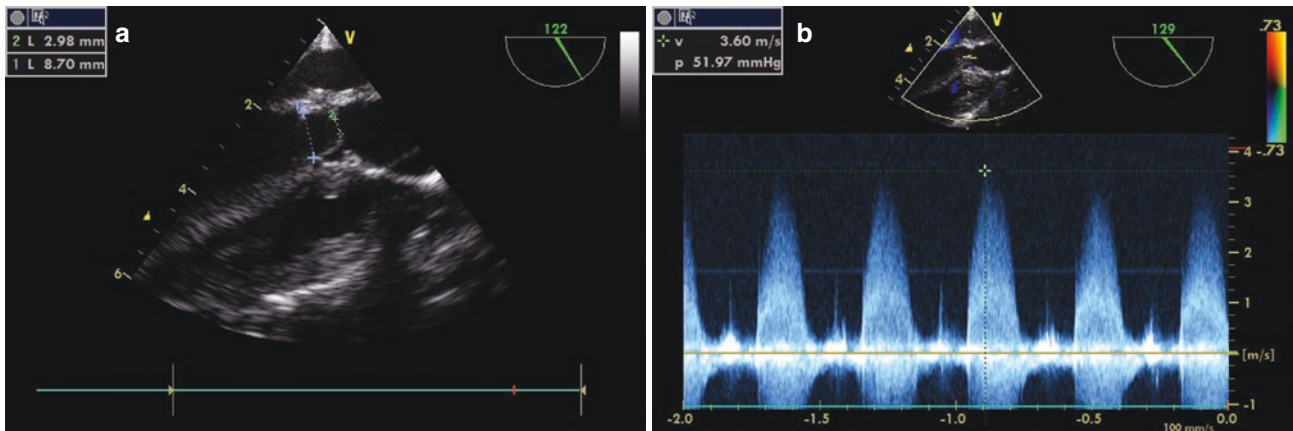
Transesophageal echocardiography demonstrates a 2-month-old girl (patient 1) with CAS. The aortic valve annulus is 8.7 mm (a). Although the peak systolic aortic valve gradient is about 52 mmHg, the ejection fraction is 31% with poor left ventricular function (b)
